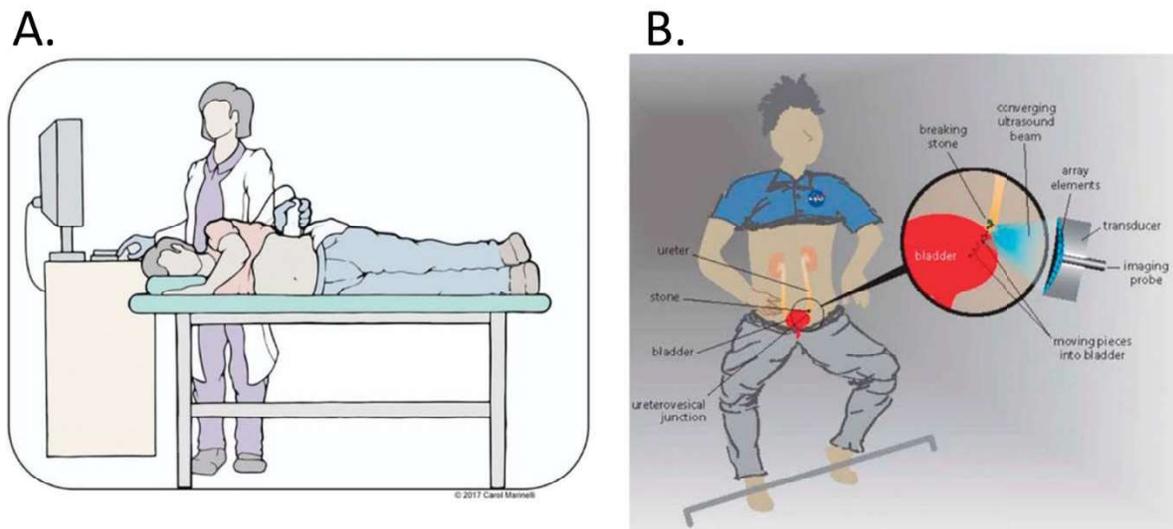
Figure modified from Hall et al.(133) showing clinical positioning and use of ultrasonic stone propulsion and transcutaneous burst wave lithotripsy in A. terrestrial setting and B. spaceflight setting.
